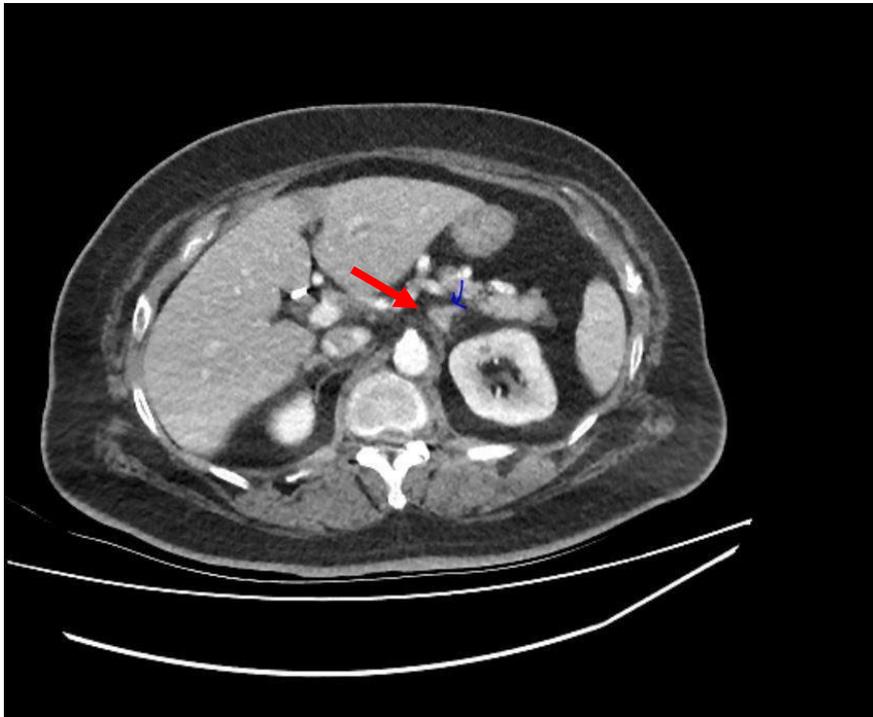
CT imaging showed a 1.5*0.9 cm left adrenal mass
